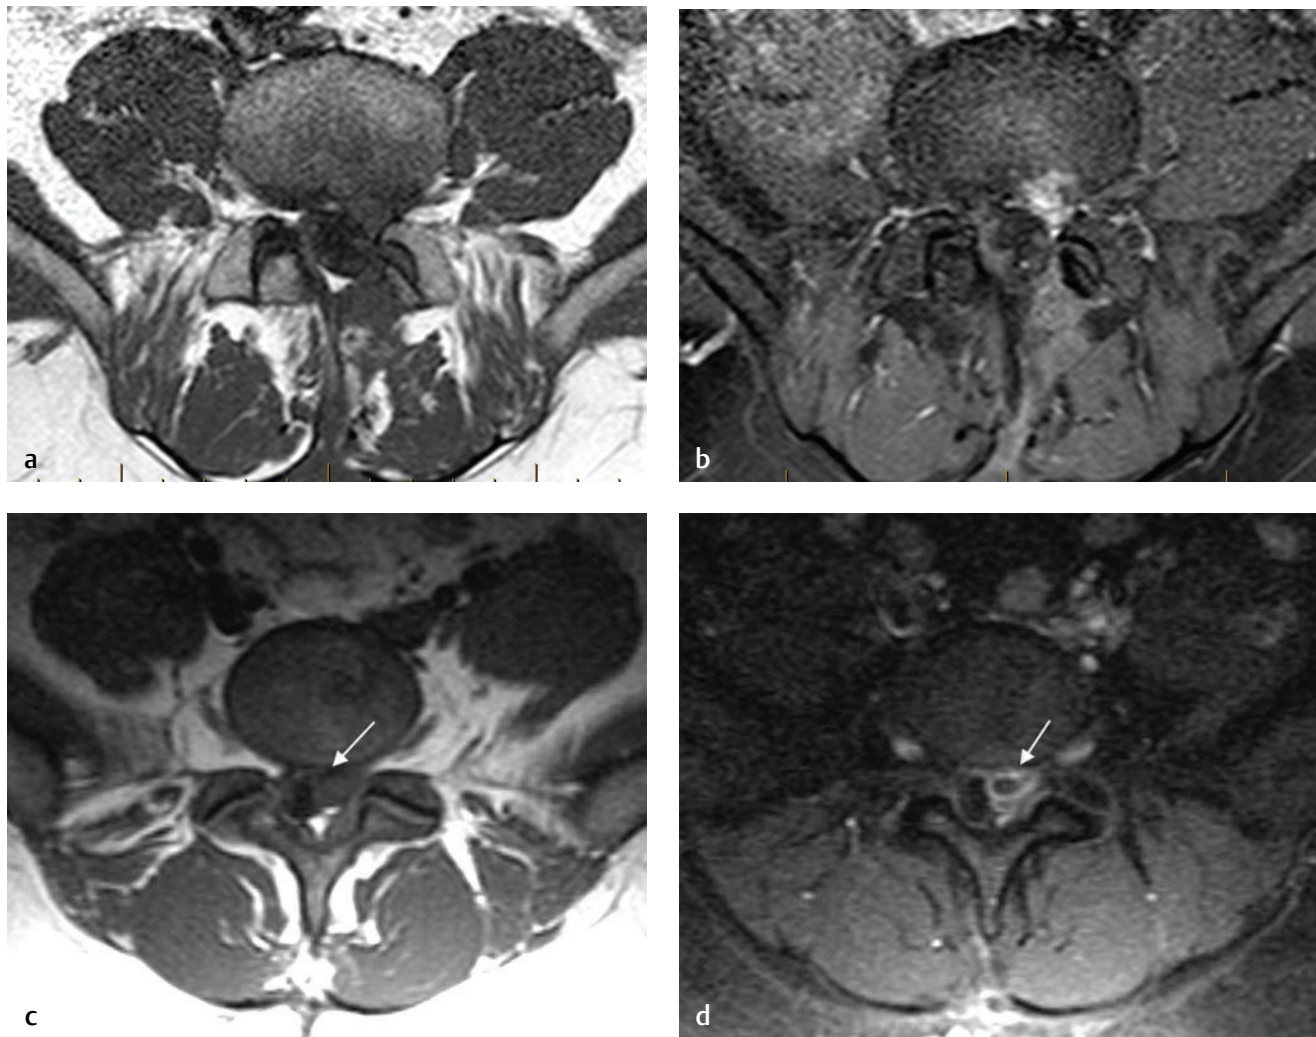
(a) Axial, noncontrast and (b) postcontrast fat-suppressed T1-weighted images show a left paracentral abnormality with homogeneous delayed enhancement, consistent with epidural fibrosis. In contradistinction, (c) axial noncontrast and (d) postcontrast fat-suppressed T1-weighted images show a left paracentral abnormality with thin peripheral enhancement (arrow on both) consistent with a recurrent disc herniation.
